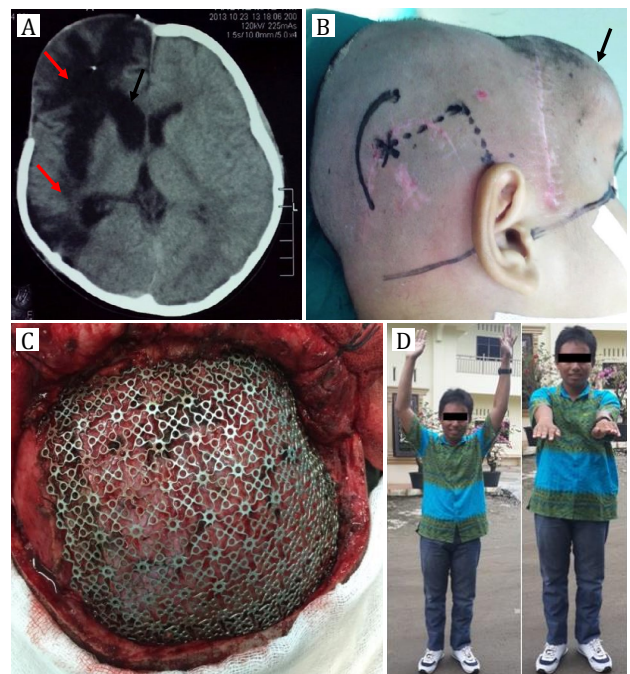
A) Two-month head CT scan after first operation, cerebromalacia along missile track fills with CSF (red arrow) and dilatation of right ventricle lateral (black arrow); B) Design incision and puncture point for VP shunt also shows bulging on the right frontal (black arrow); C) Cranioplasty with titanium mesh after VP shunt; D) Clinical presentation after 2-year follow-up shows a good outcome without any neurologic deficit
